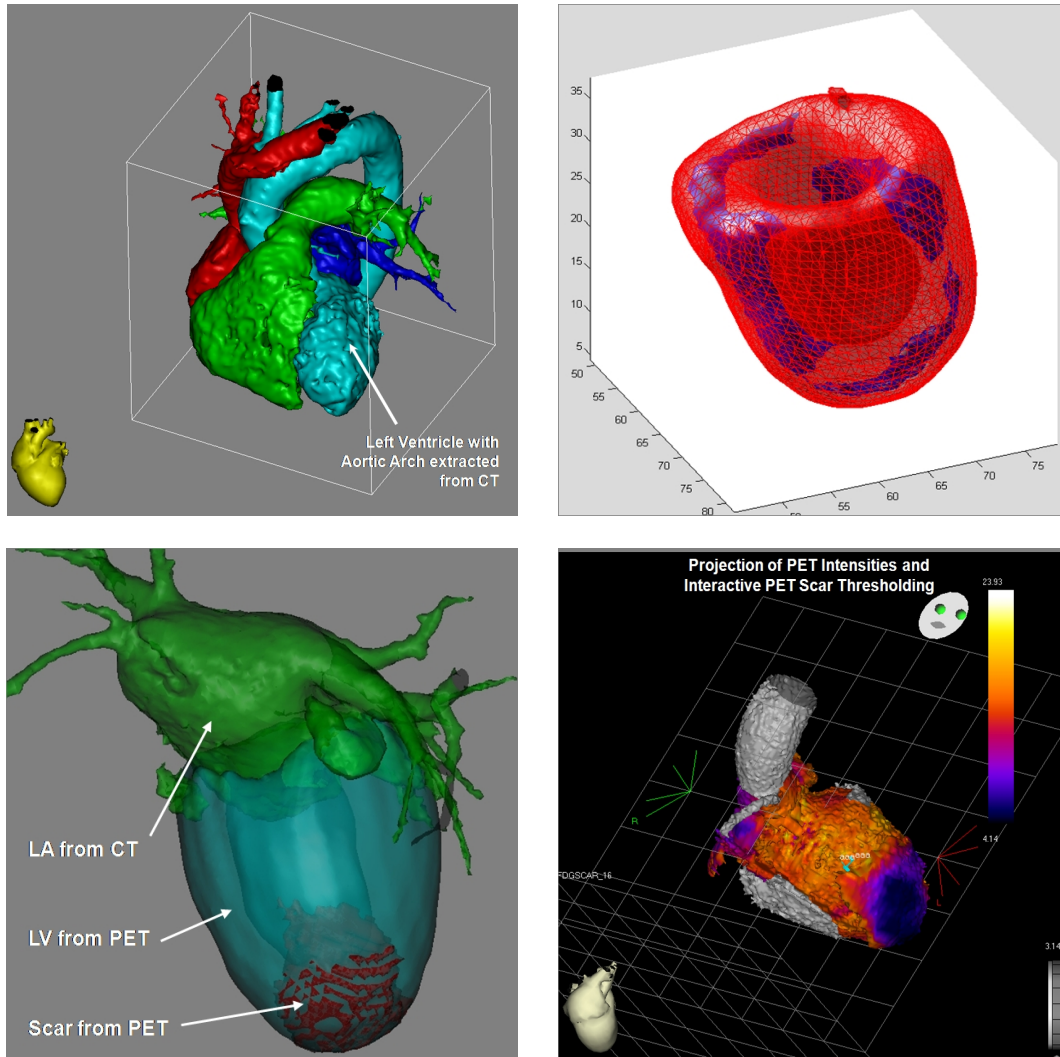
Fused visualization (bottom left) of segmented chambers (top left) and LV (top right) from CT and PET respectively assist the physician in locating the scar within the anatomy. Projections of PET intensities onto CT segmentation (bottom right) directly correlate anatomy and function for scar border zone visualization in VT ablation therapy. (Images are courtesy of Tian *et al.* [Tian 08], Kohlberger *et al.* [Kohl 06], and Biosense Webster, Israel.)
